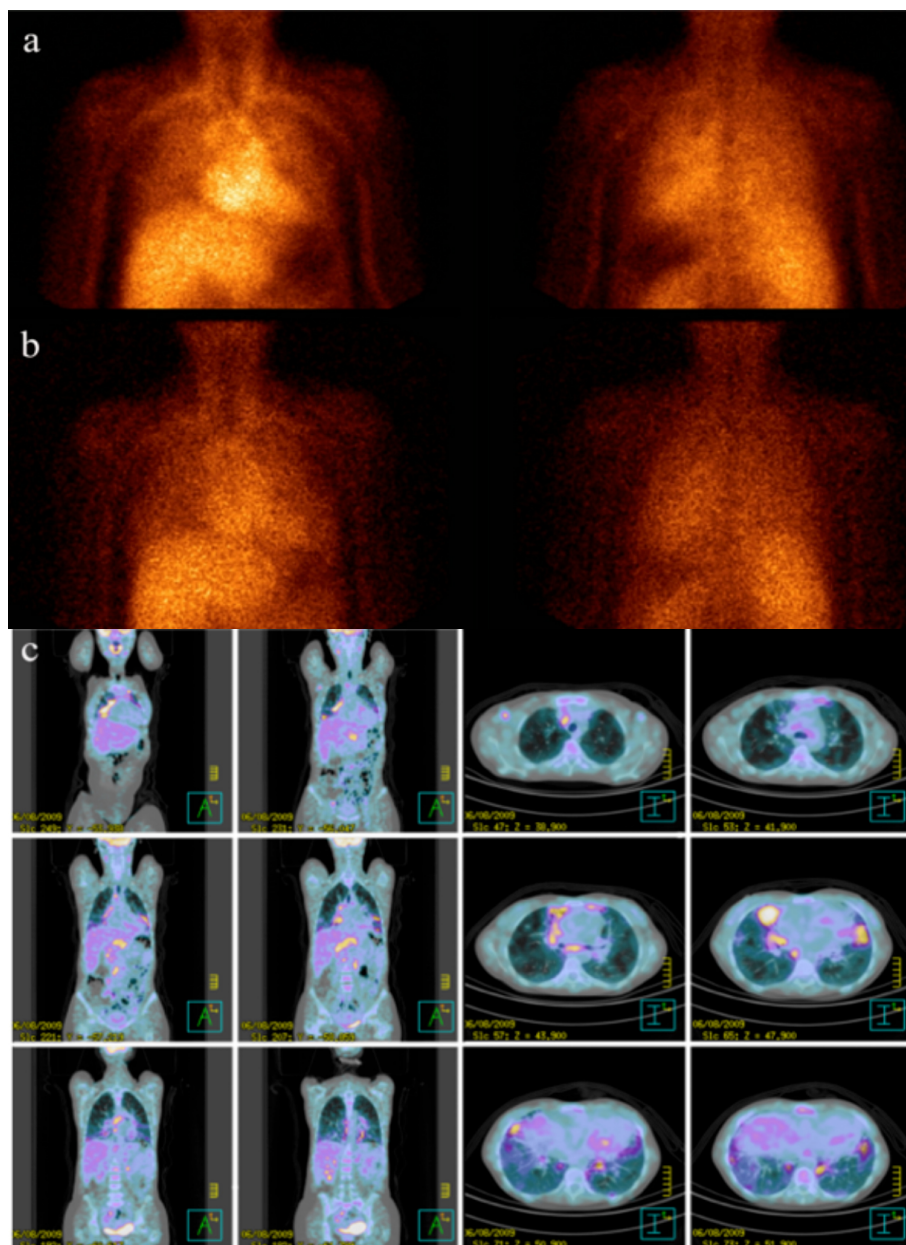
^{99m}Tc -Infliximab scintigraphy of a sarcoidosis patient (patient 4/F) acquired at 6 h (anterior and posterior views, a) and at 24 h (anterior and posterior views, b) showing a moderate and diffuse uptake in the lung parenchyma. ^{18}F -FDG-PET/CT images of the same patient showing a focal/hyleal uptake (coronal and transaxial sections, c).
